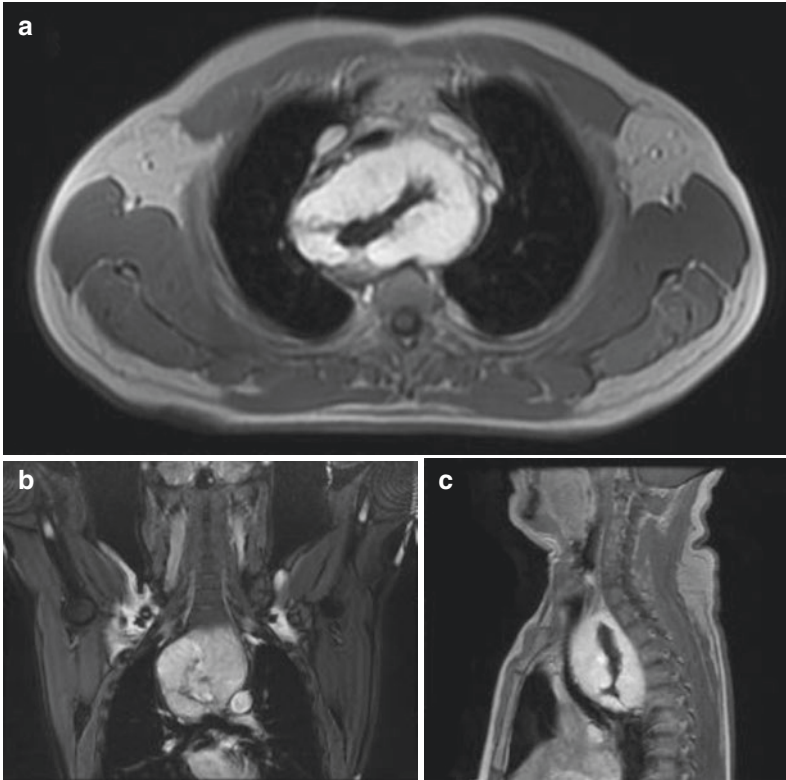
Voluminous posterior mediastinal thyroid mass with tracheal and great vessels displacement. MRI T1-w FS after intravenous contrast administration. A) Axial plane B) Coronal plane C) Sagittal plane
